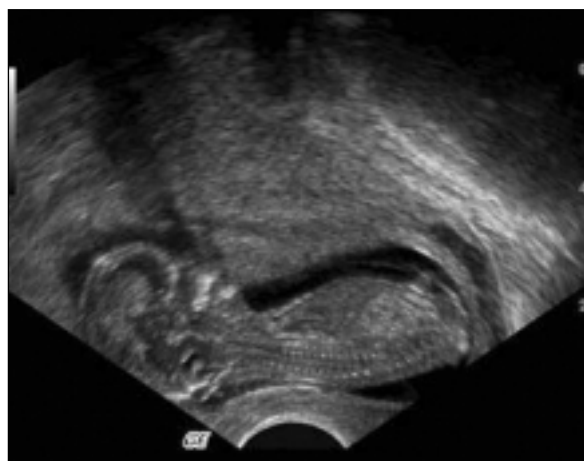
Ultrasonographic view of fetus.
